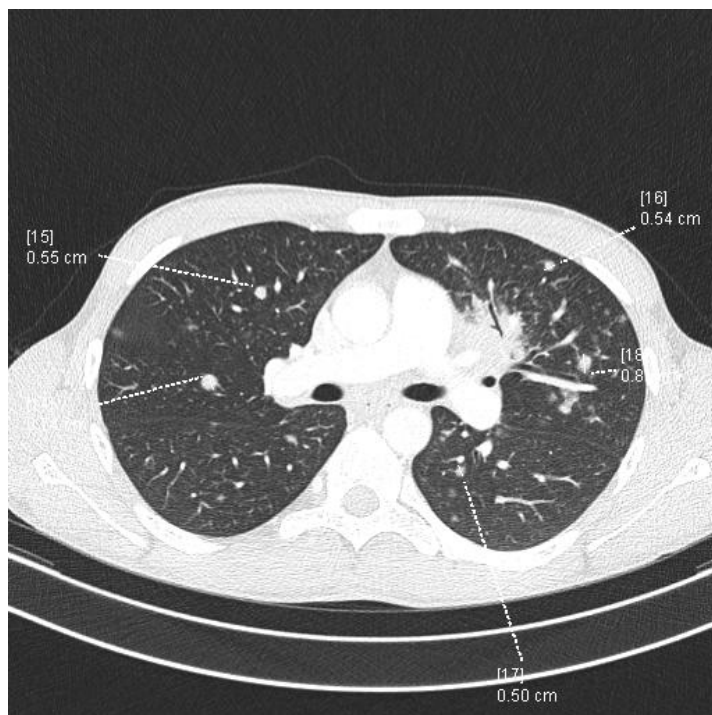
Chest CT scan of the patient. Interstitial thickening and bilateral nodules, hilar and mediastinal lymph nodes.
